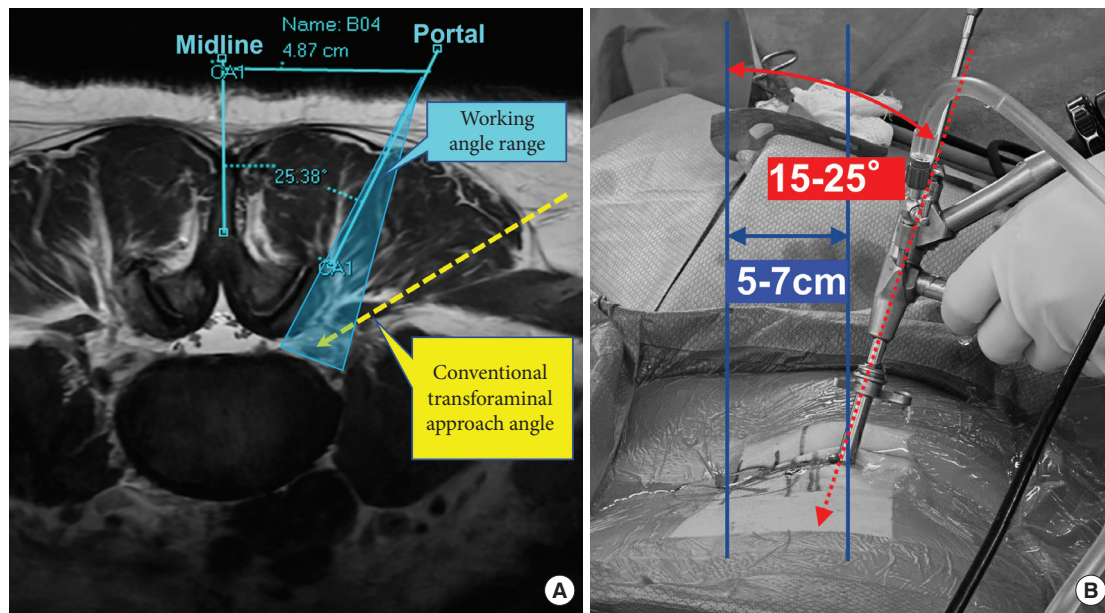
(A) An axial magnetic resonance imaging view of an L4/5 level, showing the location of the portal (about 5 cm from the midline) and the access angle in the axial plane (15° – 25° from the midline, blue lines and triangle). The conventional transforaminal access angle is demonstrated (the yellow line). (B) An intraoperative picture showing the access angle. To access the lateral recess, the angle can be increased more than 25° – 30° via a same portal, but less than a conventional transforaminal access angle which is 45° or more.
